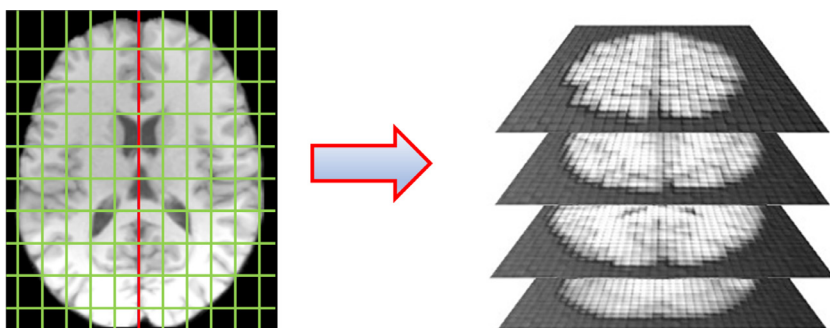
After spatial normalization, each MRI scan is divided in homologous rectangular boxes called patches.
